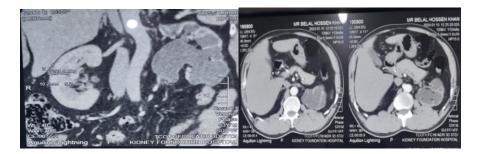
CT scan of KUB of the same patient.
